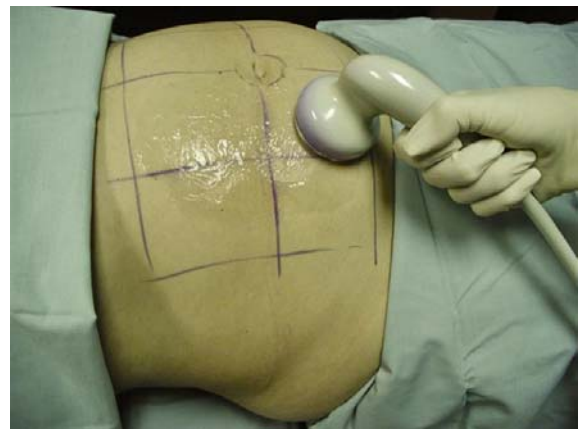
Applying external ultrasound before tumescent liposculpture
